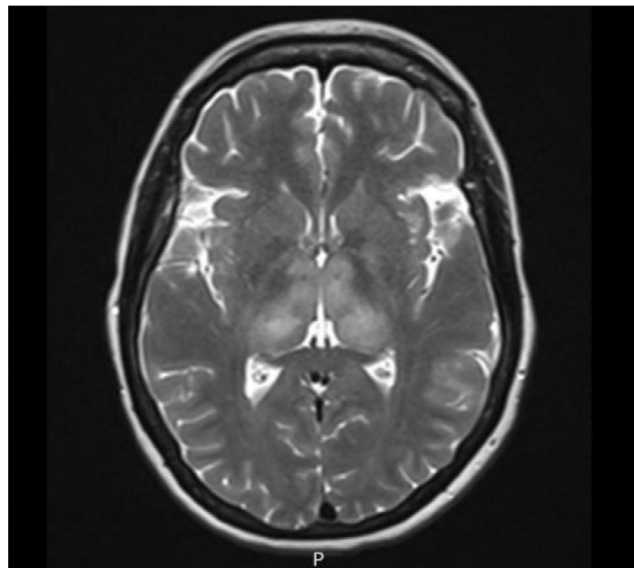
Brain lesions in MRI T2 sequence
